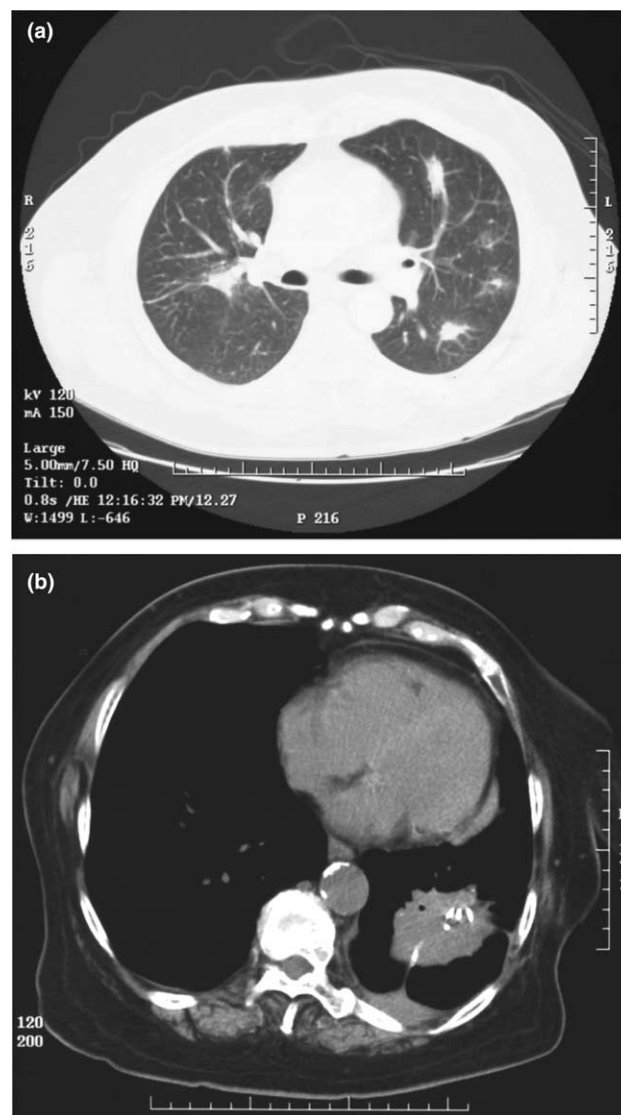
(a) Bilateral lung nodules: CT scan shows bilateral multiple, irregularly shaped nodules. (b) Lung mass: CT scan shows a large irregular mass in left lower lobe with presence of punctate calcification. There is a pleural tag with adjacent pleural thickening.
